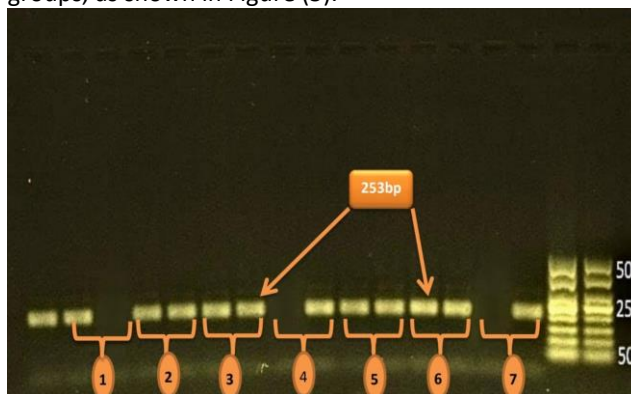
Agarose gel electrophoresis image that show the SSP-PCR product analysis of IL-4 gene (-590 C/T) in infertility male samples. SSP-PCR product was analysis by 1% agarose gel . Where M: marker (50bp – 1000bp), lane CC wild type homozygote was shown at the bands sample (1), lane CT mutant type heterozygote was shown at the following bands samples (2,3,5 and 6) and lane TT homozygote was shown in bands samples (4 and 7).
